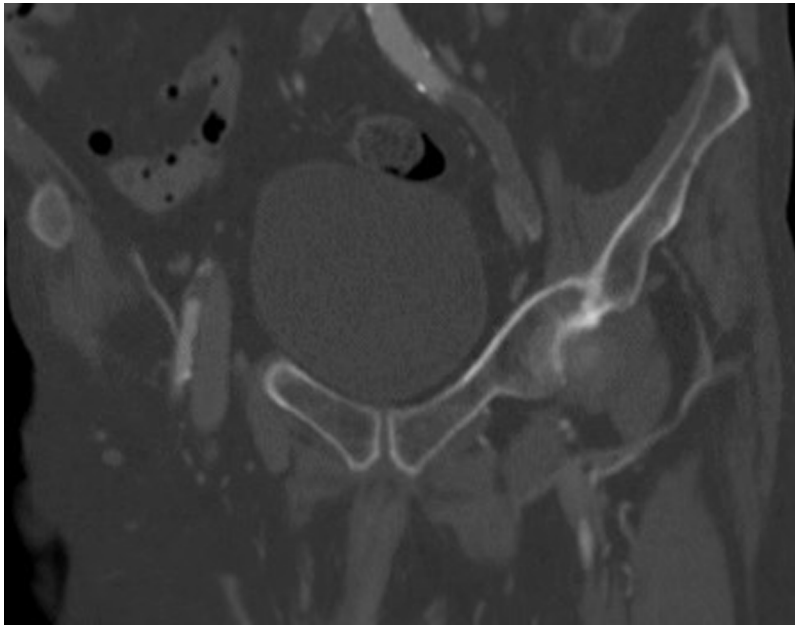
Computed tomography angiography demonstrating acute occlusion of the left external iliac artery.
